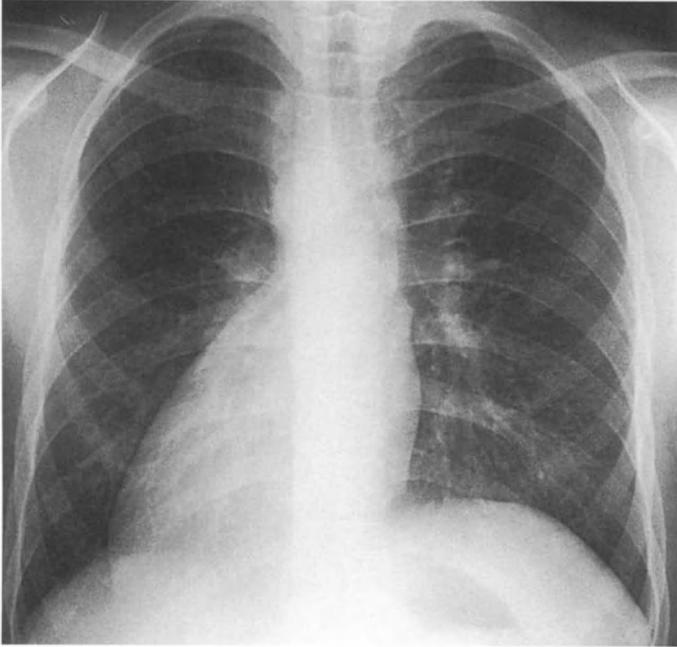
Chest radiograph of a 13-year-old boy with left isomerism and dual AV nodes and His bundle
